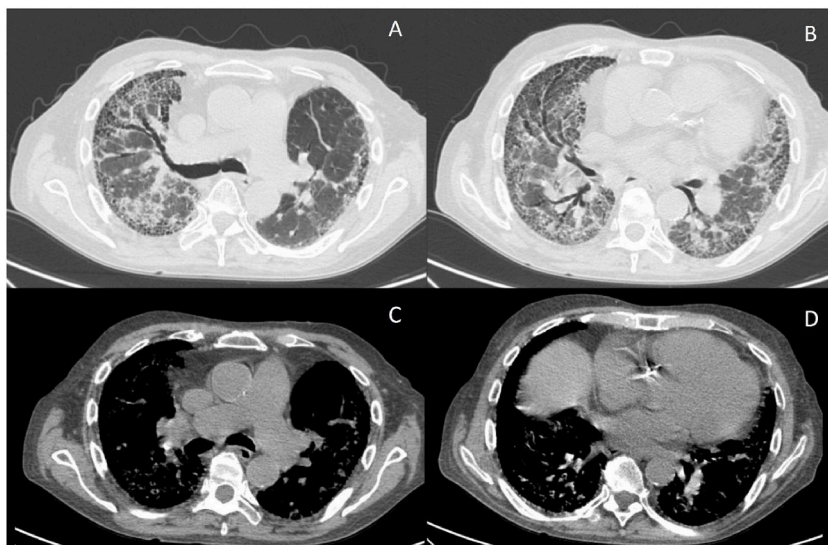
Chest magnetic resonance imaging of the patient presented in this case. Areas of groundglass pattern in the bilateral axial interstitium were observed. There were also several subpleural cyst mainly in the lower lobes associated with traction bronchiectasis.
